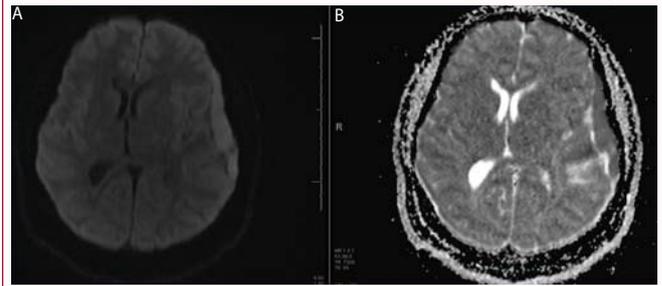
(A) 3T Brain MRI DWI sequence. (B) ADC Map Sequence. Restricted diffusion pattern seen in the left convexity extra axial lesion (Arrows).
